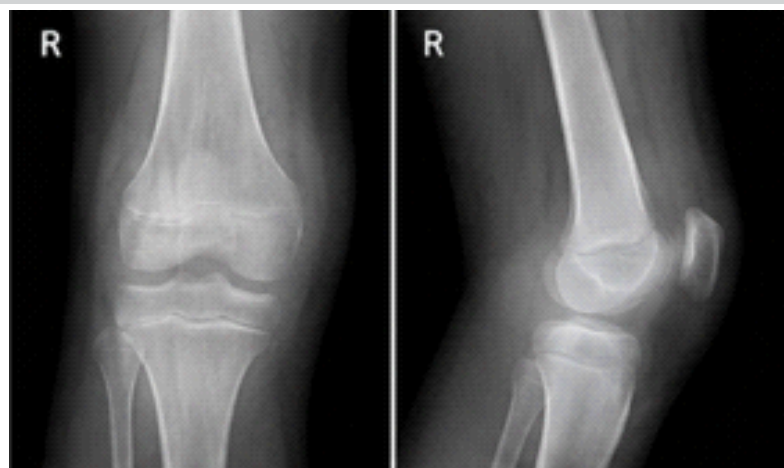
Pre-operative radiographs of right knee (anteroposterior and lateral views) in a 10-year-old boy showing joint effusion with soft-tissue swelling and preserved bone contours.
